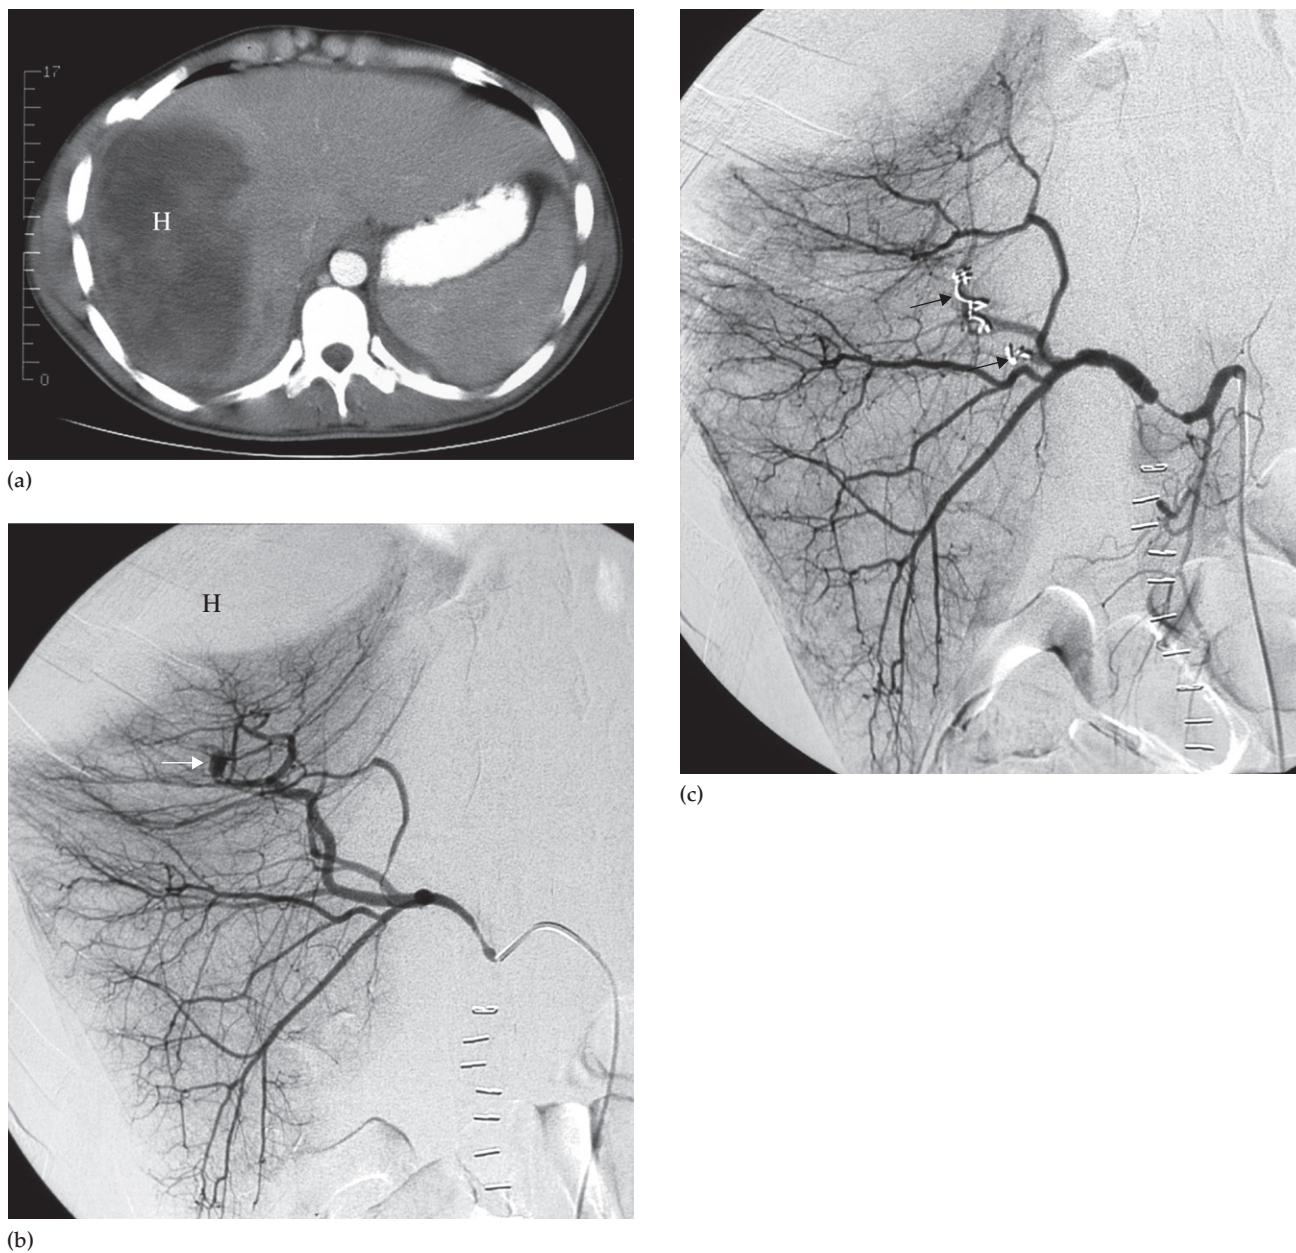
Therapeutic embolization. (a) CT scan in a patient with a large intrahepatic haematoma (H) following a road traffic accident. (b) Selective hepatic arteriogram showing a false aneurysm (arrow) which was the site of bleeding. Note the haematoma (H) compressing the liver substance. (c) A branch of the hepatic artery supplying the aneurysm has been occluded with coils (arrows) and the aneurysm no longer fills.
